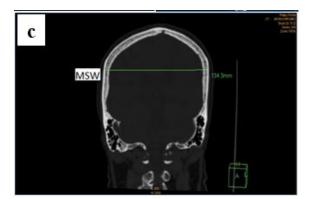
CT image showing the MSW
